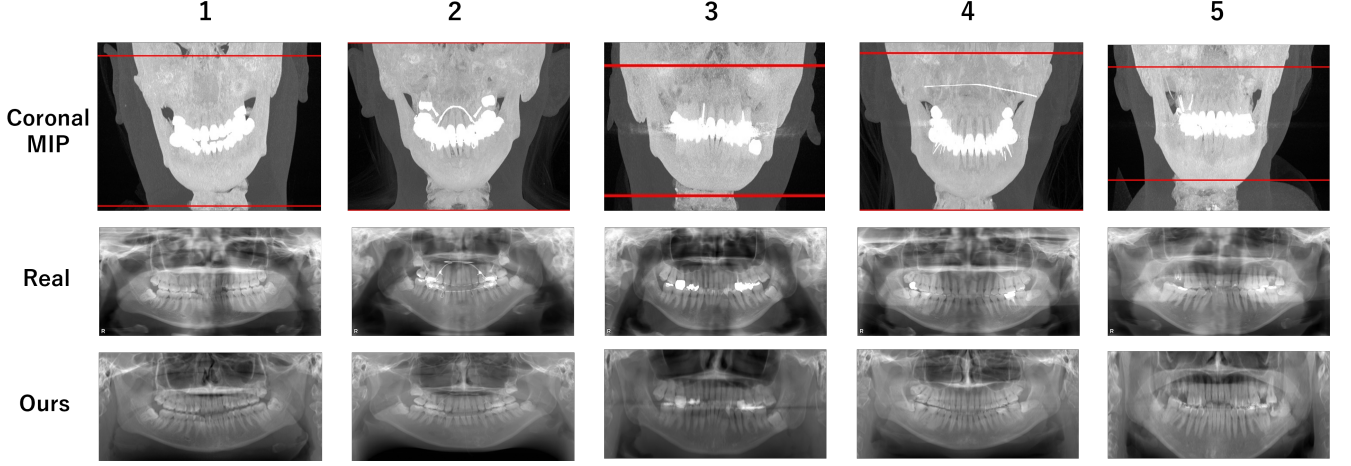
Visual comparison of synthesized panoramic X-ray images and original X-ray images.
